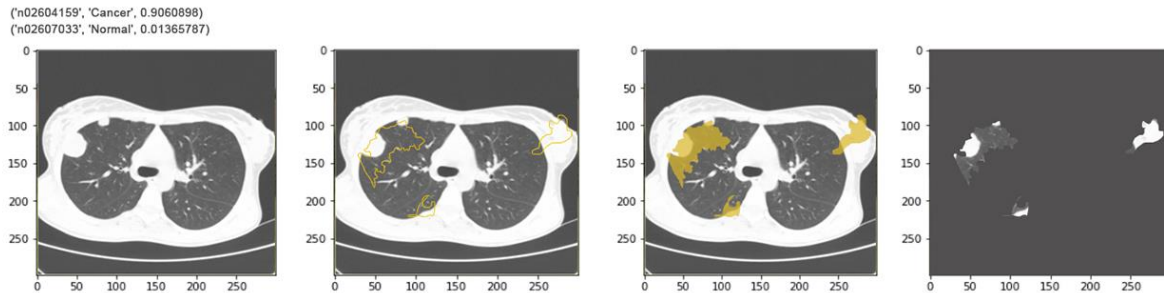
LIME result of CT image with a model of Xception
